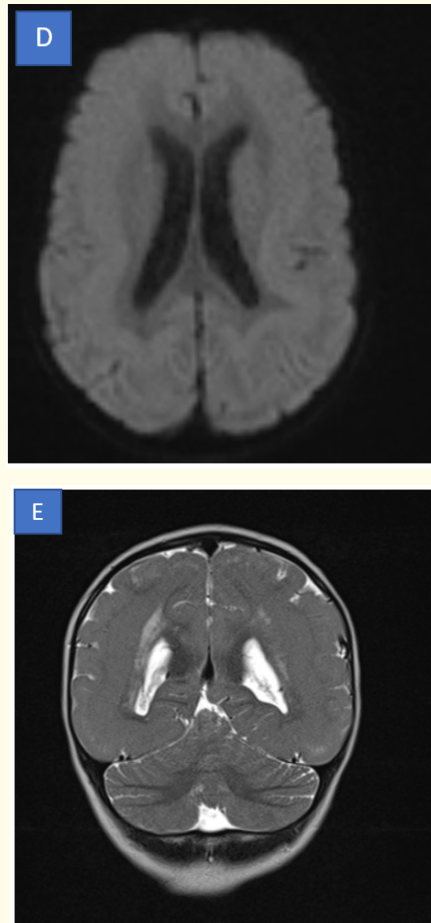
Objectifying brain MRI: Punctate and clumped periventricular subcortical signal anomalies, more pronounced near the occipital horn of the right lateral ventricle, with iso T1, hyper T2 (A), and flair (B) signals without diffusion sequence abnormalities (C), and no enhancement after GADO injection. There is also dedifferentiation of the white-gray matter with a reduction of white matter and a gyration anomaly characterized as pachygyria (E). A: Axial section: T2, B: Axial section: T2 Flair, C: Axial section: Diffusion, D: Axial section: Echo grad, E: Coronal section: T2.
